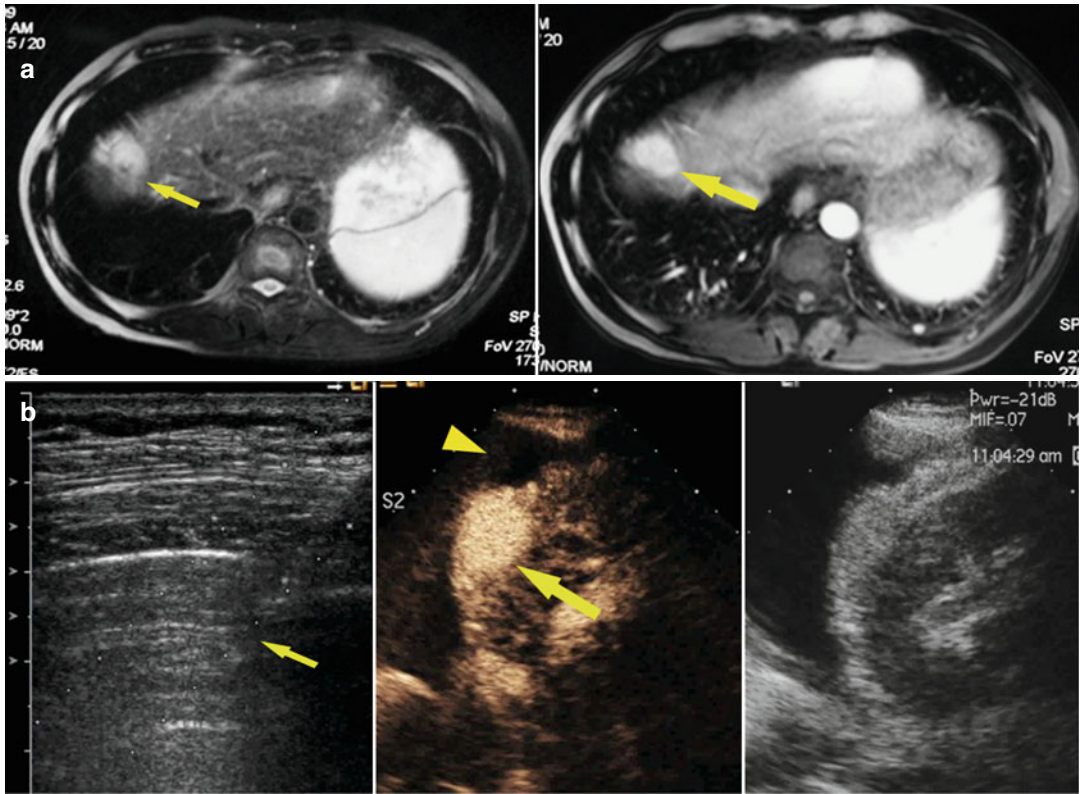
Images in a 58-year-old man with 2.6 cm hepatocellular carcinoma treated by percutaneous MWA with artificial pleural effusion. (a) Contrast-enhanced MRI before MWA shows the neoplasm appearing as a high signal on T2WI (*small arrow*) and in hyper-enhancement (*large arrow*) on arterial phase. (b) *Left* sonogram shows the puncture of the pleural cavity with a 16-gauge BD angiocath needle (*small arrow*). The *middle* sonogram shows the hyper-enhanced nodule on contrast-enhanced
